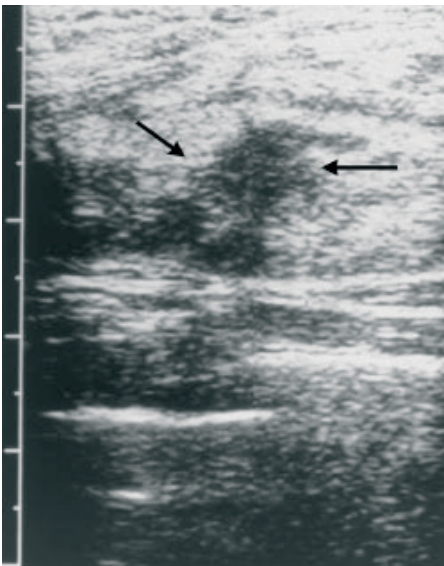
Ultrasound clearly shows an irregular hypoechoic lesion in the right breast confirming the suspect lesion detected at MRI in patient B.
